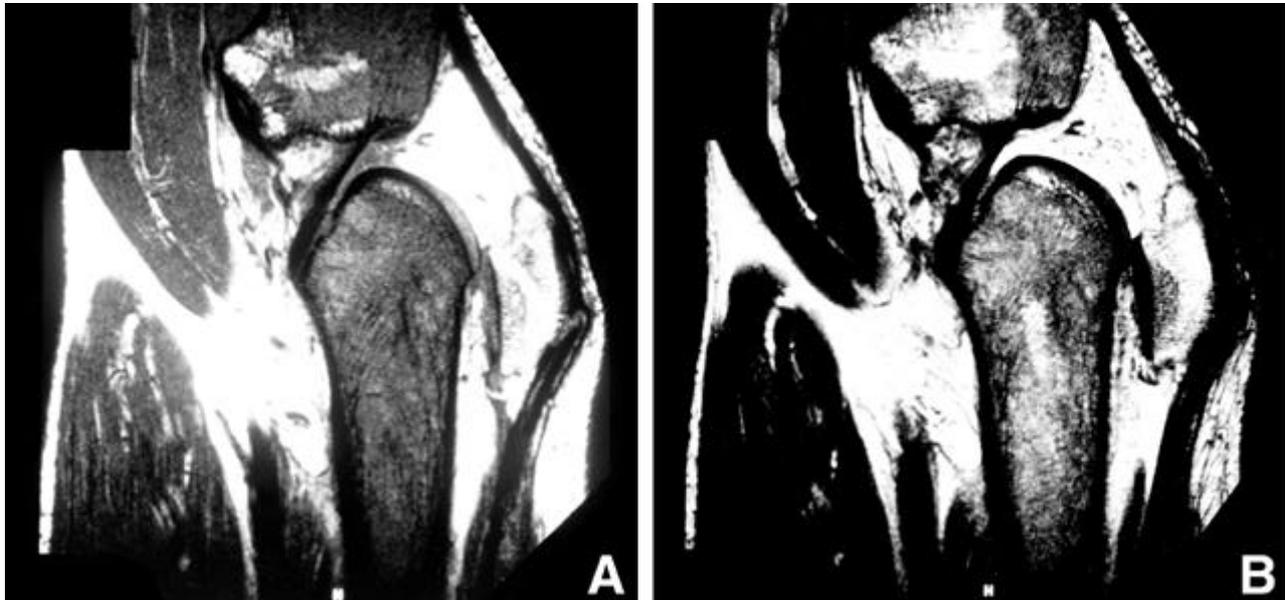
A: T1-weighted sagittal image of the knee shows diffusely low signal intensity of the marrow cavity in the femur and the tibia. B: T2-weighted coronal image of the knee shows heterogeneously low and high signal intensity.
